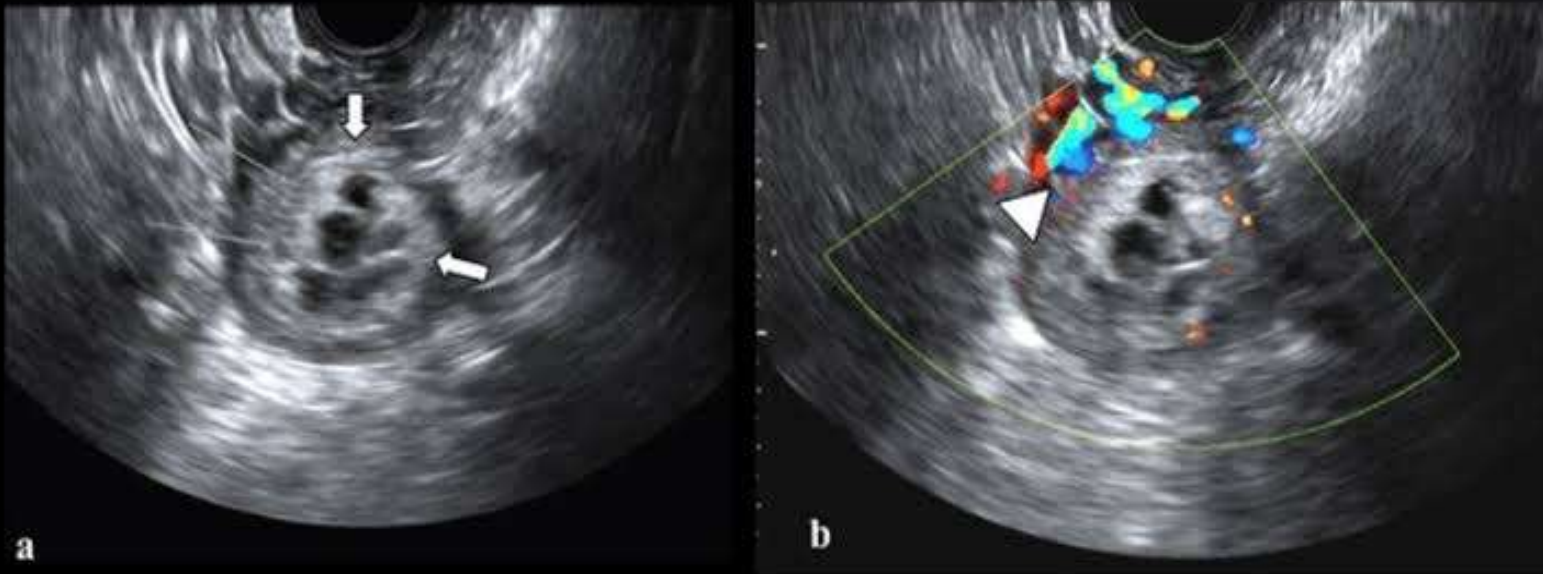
Choriocarcinoma (a) Transverse transvaginal sonography (TVS) image of the uterus shows infiltrative heterogeneous mass distending the uterine cavity (thick arrows) and ill definition of the myometrium in the right side (thin arrows) indicative of invasion of the myometrium. (b) Color flow Doppler shows areas of increased vascularity mainly in the right side (arrowhead).
